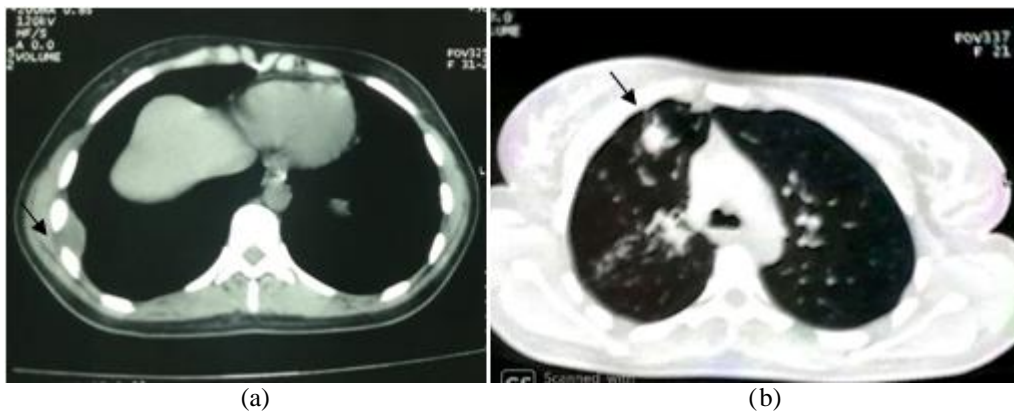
Chest CT: a) Mass of heterogeneous density at the level of the 8th intercostal space b) bilateral upper lobar pulmonary nodules
